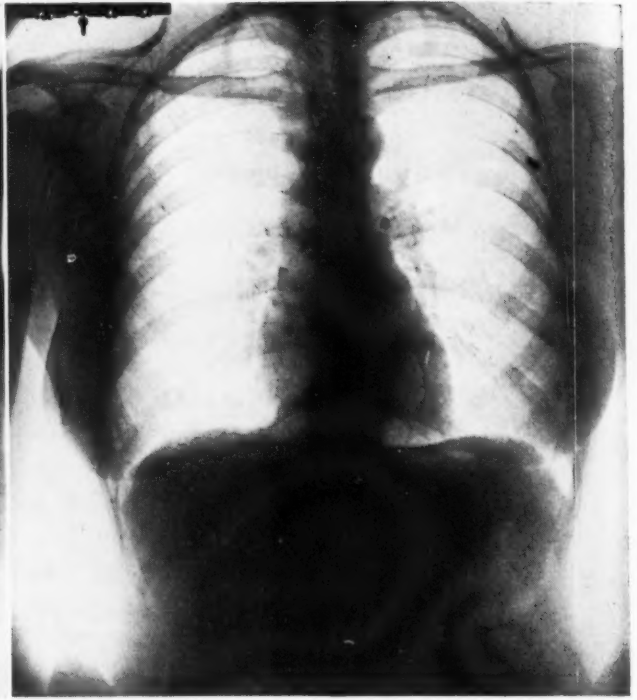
Chest x-ray of Mrs. L. S. showed many calcified hilar glands.
